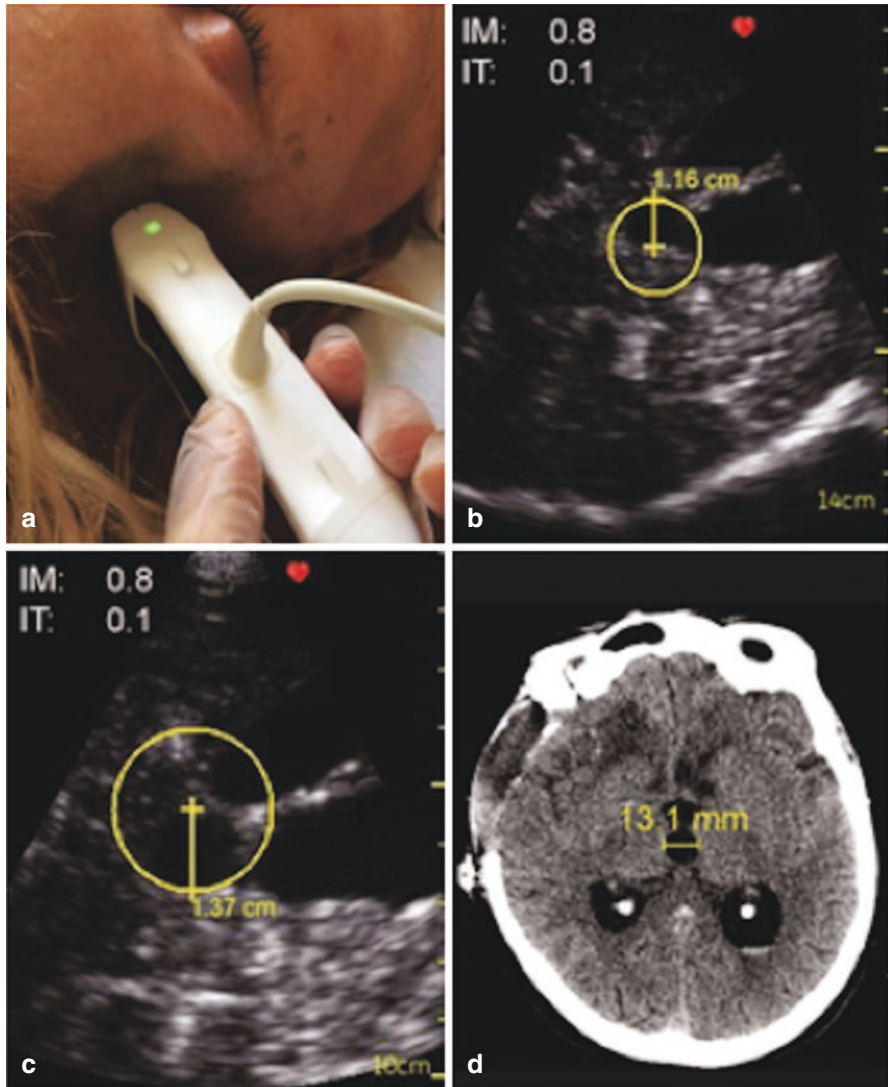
(a) TCCS: Transtemporal acoustic window. (b) TCCS showed a measurement of the third ventricle at around 1.16 cm. (c) TCCS showed a dilated third ventricle measuring 1.37 cm. (d) CT scan showed a dilated third ventricle measuring 13.1 mm. (Courtesy: Najjar et al. Crit Ultrasound J (2017) 9:17)
